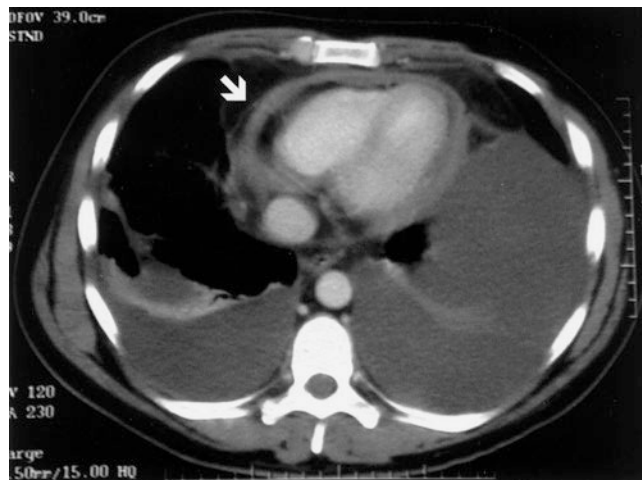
Computed tomographic scan of the heart with pericardium measuring >10 mm thick (arrow)
